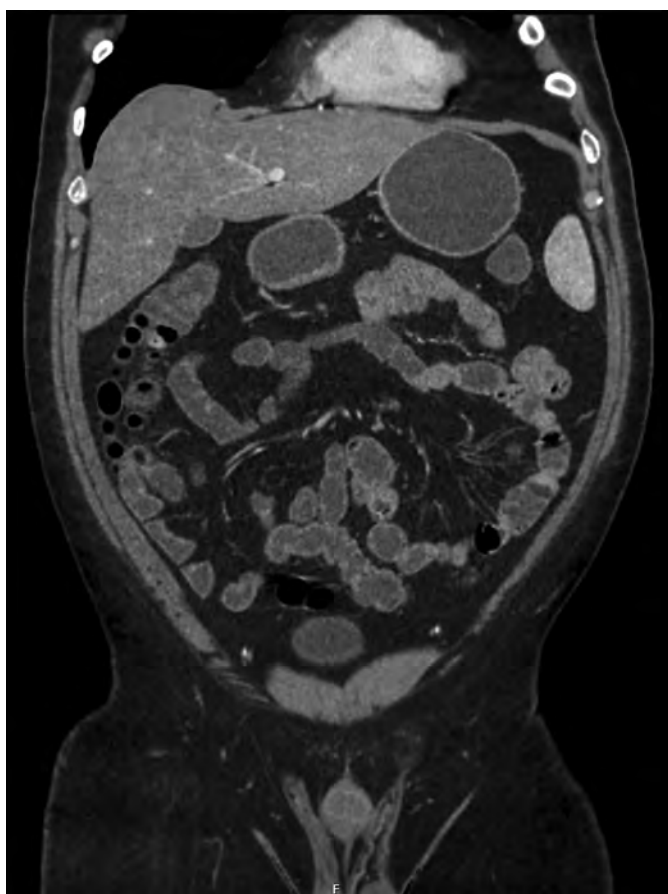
Computed tomography enterography of the abdomen and pelvis performed before patient's discharge without the previously observed abnormalities (identical coronal plane as Fig. 1).
